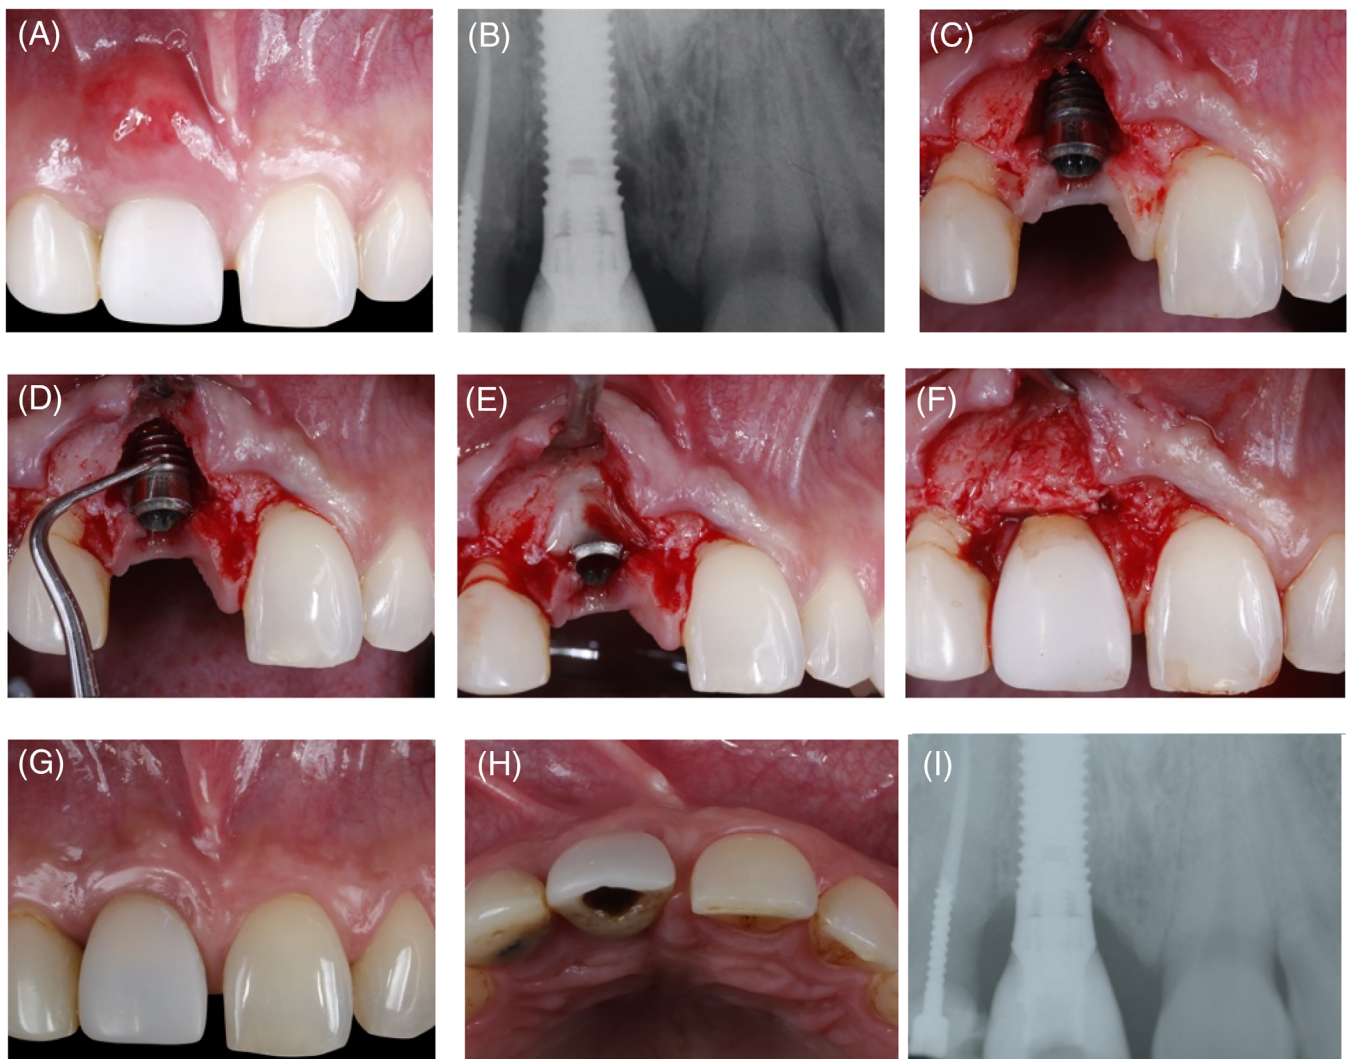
(A) Bone level implant located in the central incisor (exhibiting recurrent events of spontaneous suppuration under palpation). (B) Periapical x-ray showing peri-implant bone loss (C) Note the class Ib peri-implantitis bone defect where the implant is within the alveolar envelope. A papilla preservation flap and intra-sulcular incisions of the adjacent teeth are performed to gain access. (D-E) Surface detoxification is applied by means of a plastic-tip ultrasonic device and ethylenediaminetetraacetic acid (EDTA) for 2 min. (F) Autogenous bone harvested from the maxillary tuberosity is used as bone grafting material. (G) A connective tissue graft is used to compensate the thin mucosal phenotype (H) Enamel matrix derivative was applied on top to promote soft tissue healing. (I-J) Disease resolution at two-year follow-up is noted (buccal and occlusal views), without significant esthetic sequelae. (K) Radiographic analysis showing bone filling.
